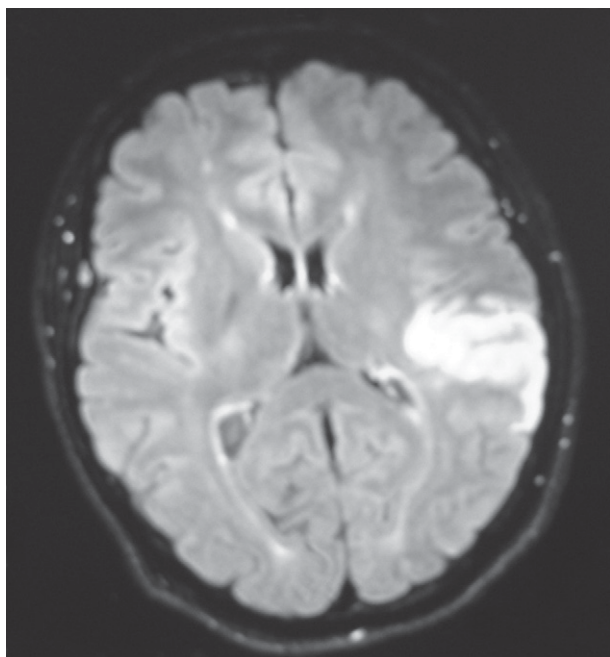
Axial T2 – weighted magnetic resonance image showing the acute left middle cerebral artery infarct.
